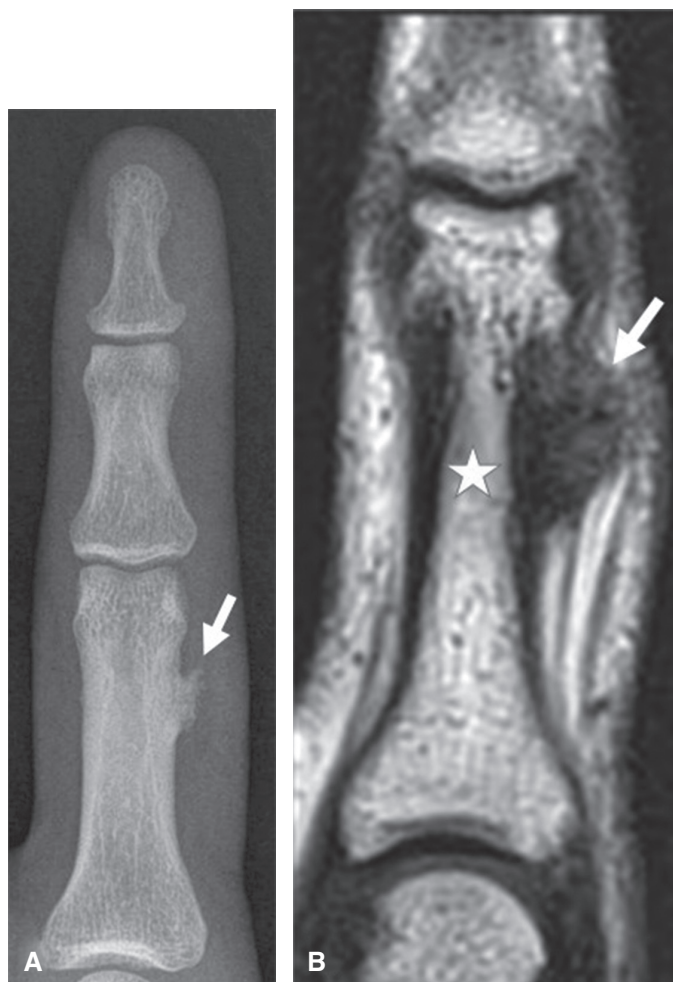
Bizarre parosteal osteochondromatous proliferation. *A:* PA radiograph of the long finger shows a parosteal lesion (*arrow*) arising from the diaphysis of the proximal phalanx with questionable intramedullary contiguity. *B:* Coronal, T1-weighted, MR image of the same region shows that the lesion (*arrow*) has mixed dark and intermediate signal. There is absence of intramedullary contiguity, as the lesion contains no T1 hyperintense bone marrow signal (*star*). There was no associated bone marrow edema or soft tissue edema on T2-weighted, fat-saturated MR images (not shown).
